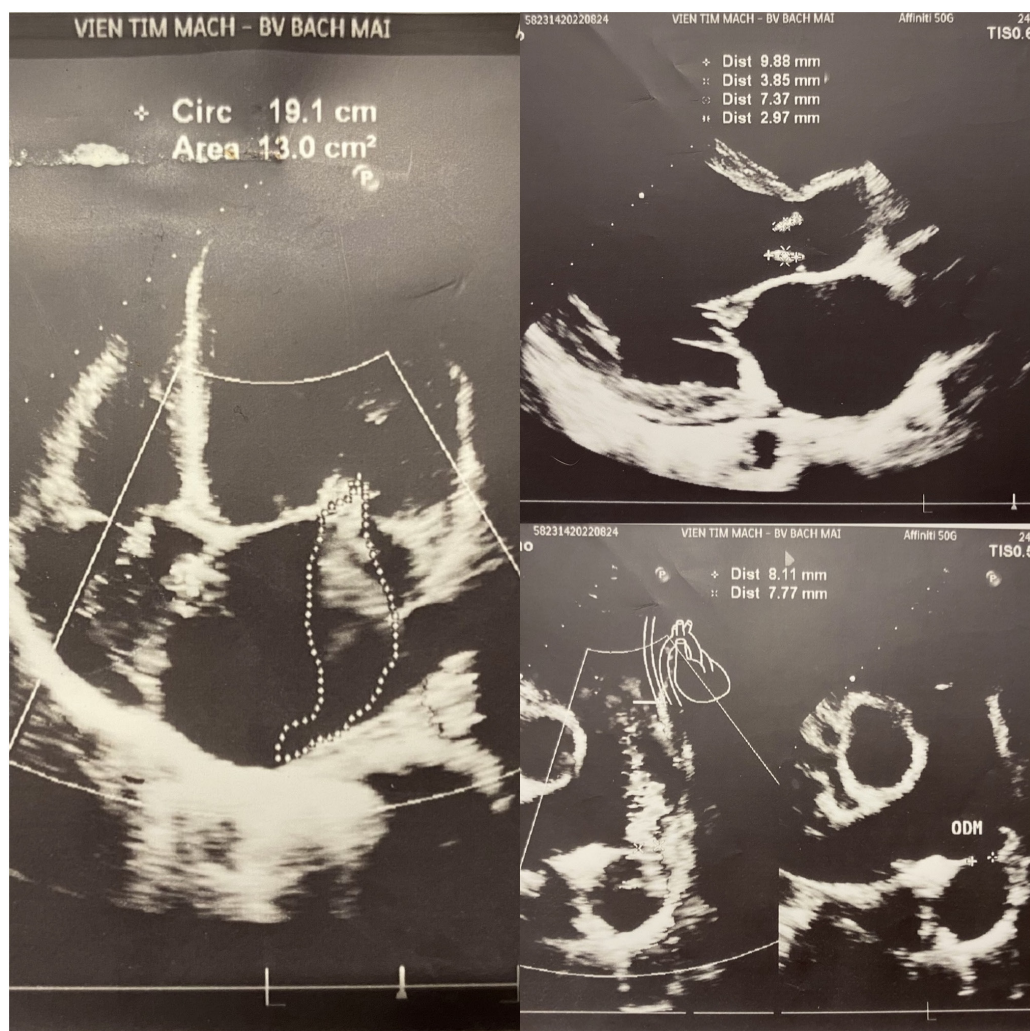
Doppler echocardiography of the patient with culture-negative endocarditis. There were both mitral and tricuspid valve lesions in doppler echocardiography of the patient with culture-negative endocarditis. The depicted images are from the same patient. The echocardiogram revealed severe aortic regurgitation, aortic valve vegetations, severe mitral valve regurgitation due to dilated valve annulus, moderate tricuspid valve regurgitation, remaining ductus arteriosus (6 mm in length) and a pulmonary artery diameter of 6.4 mm. Small vegetations were also observed in the ductus arteriosus and pulmonary artery.
